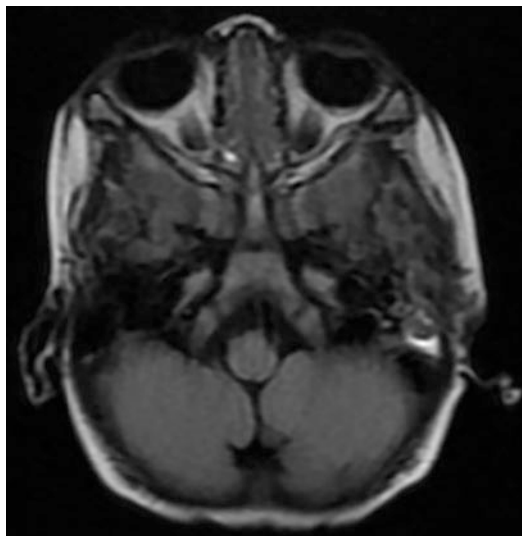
Coronal cut contrasted magnetic resonance imaging showing the same soft-tissue lesion involving the left temporal bone, left temporalis muscle and left mastoid air cells
